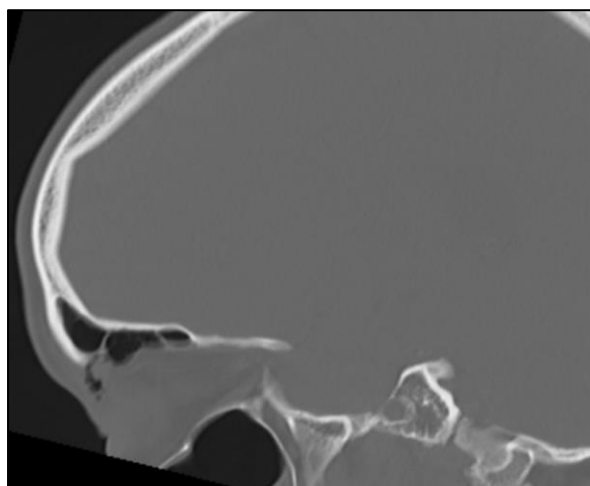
Sagittal view of the CT bone window showing a displaced bone fragment in the right frontal sinus.
